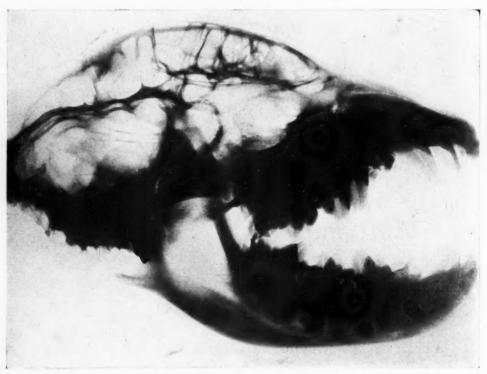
Radiograph of skull of hyena.
